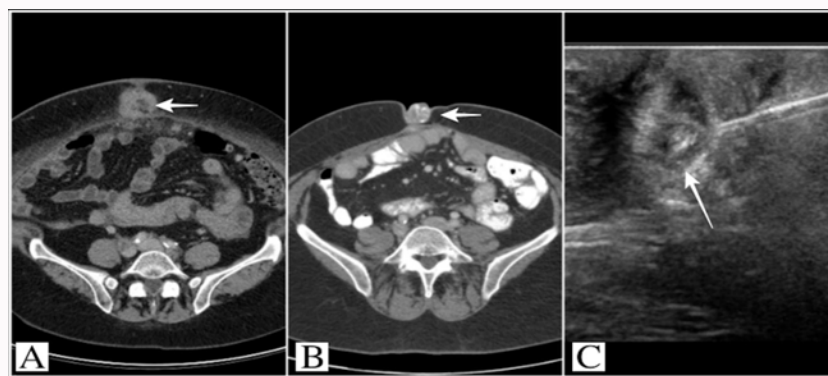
A and B) Images of CT axial sections showing the SMJN (arrows) and C) Ultrasound-guided core needle biopsy of an umbilical nodule.
